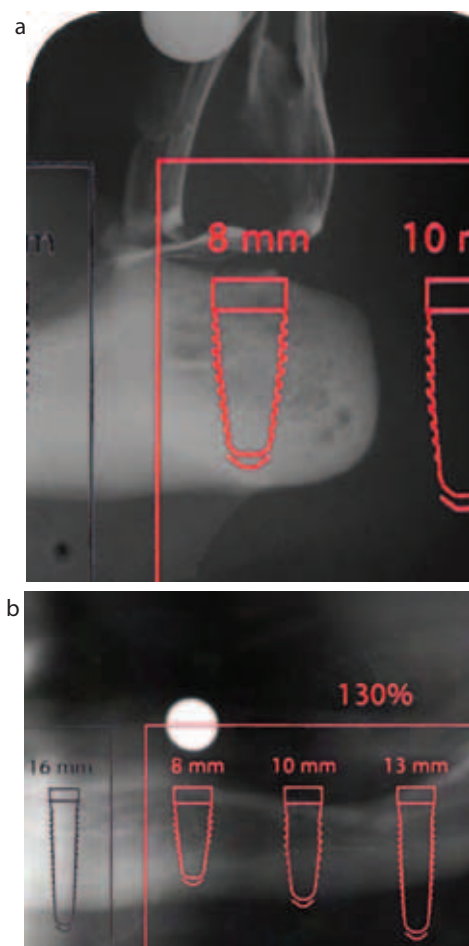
(a, b) Translucent overlays supplied by implant manufacturers can be used on both panoramic and transsymphyseal radiographs to assist in planning. The overlay shown is by Nobel Biocare.
